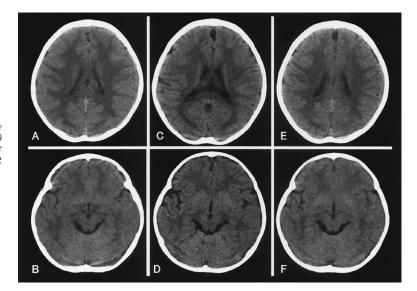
Serial brain CT. (A, B) Two years before alteration in consciousness. (C, D) On admission. (E, F)Two months after discontinuation of valproic acid. Observe normal findings in A and B, as well as E and F, contrasting with mild atrophic changes in the cerebrum in C and D.
